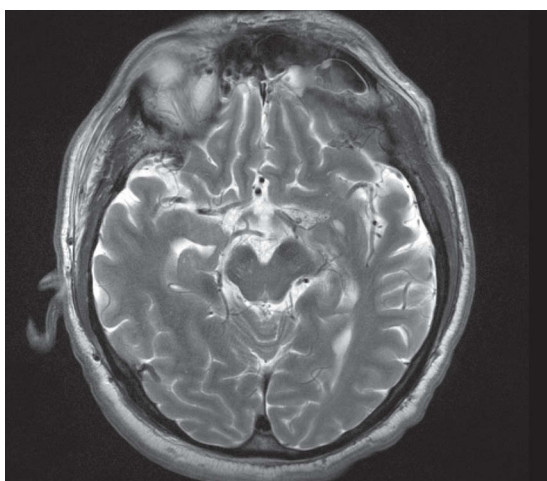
T2 axial MRI scan, showing resolution of the previous image alterations.
